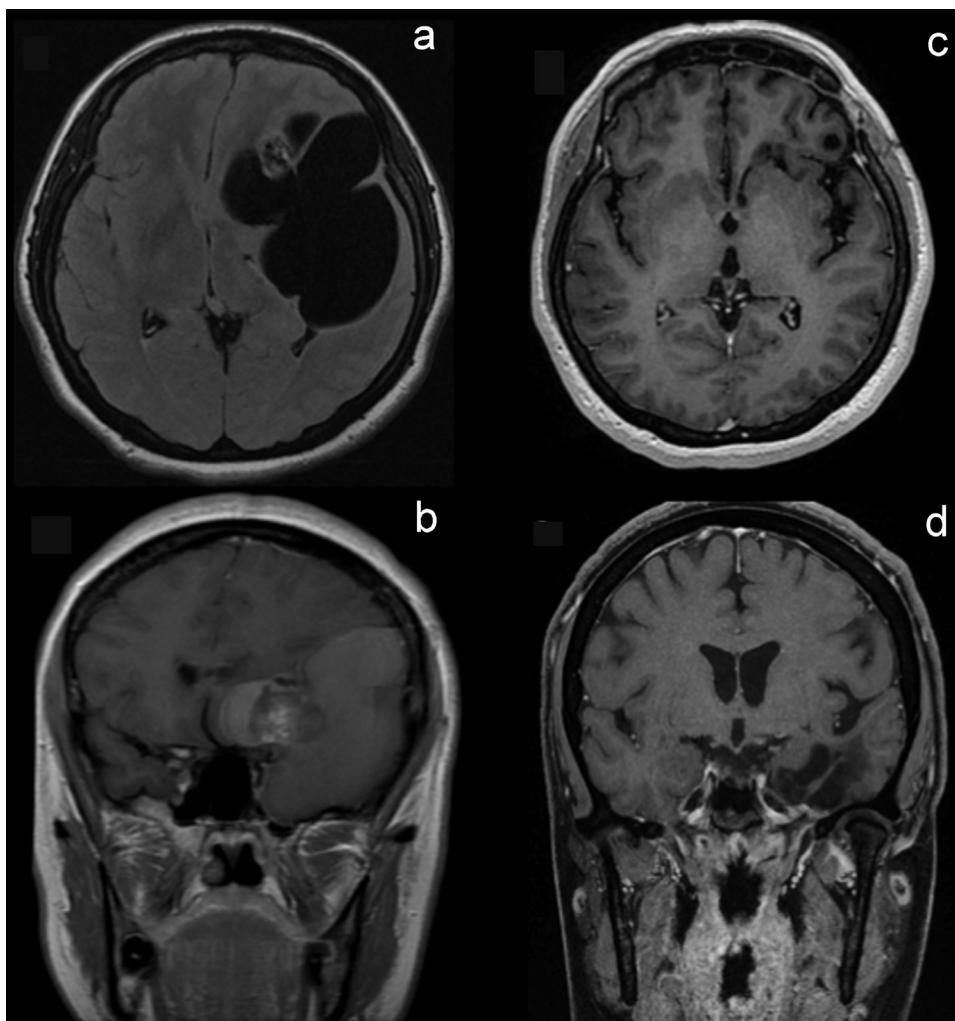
Preoperative MRI (A and B) notice that midline structures and sellar compartment is not involved. Postoperative MRI (C and D) after 27 months revealed no residual tumor.
